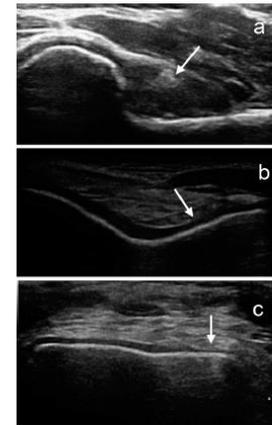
Examples of subclinical ultrasound findings. (a) Grade 1 synovitis in the radial recess of the elbow (arrow). (b) Grade 1 chondral damage in the femoral thurachlea of the knee (arrow). (c) Grade 1 chondral damage in the talar dome of the ankle (arrow).
